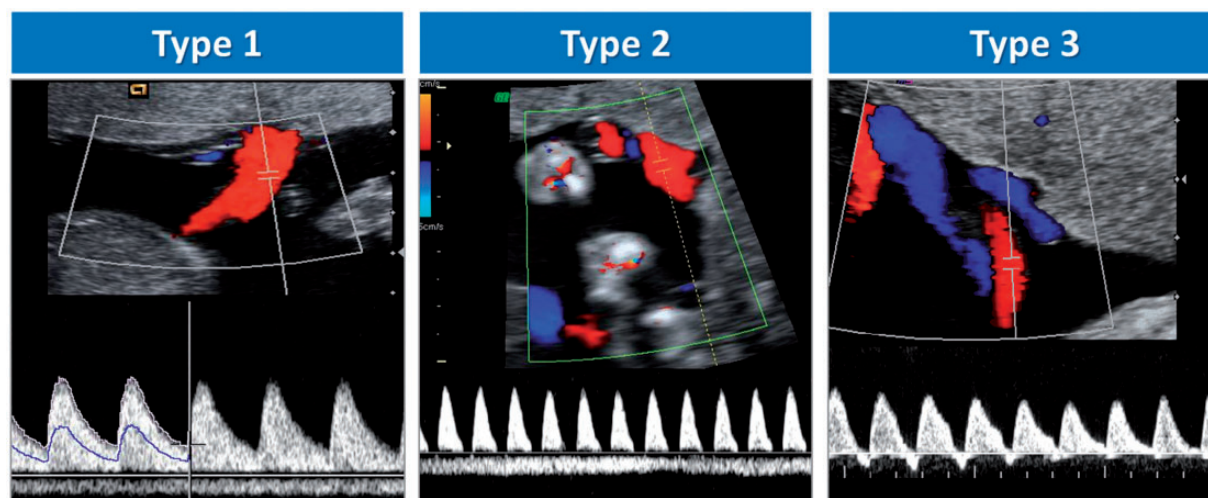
Patterns of umbilical artery Doppler flow in selective fetal growth restriction [author's own images].
